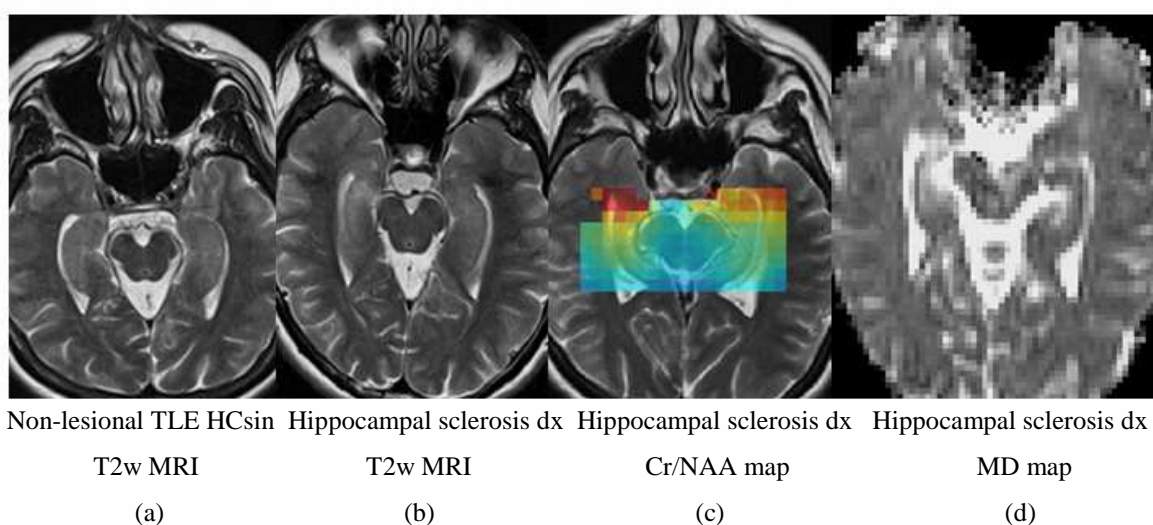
T2-weighted MR images in a) a patient with non-lesional left temporal lobe epilepsy and b) a patient with right hippocampal sclerosis. c) The metabolic map and d) the map of mean diffusivity in a patient with right hippocampal sclerosis.
